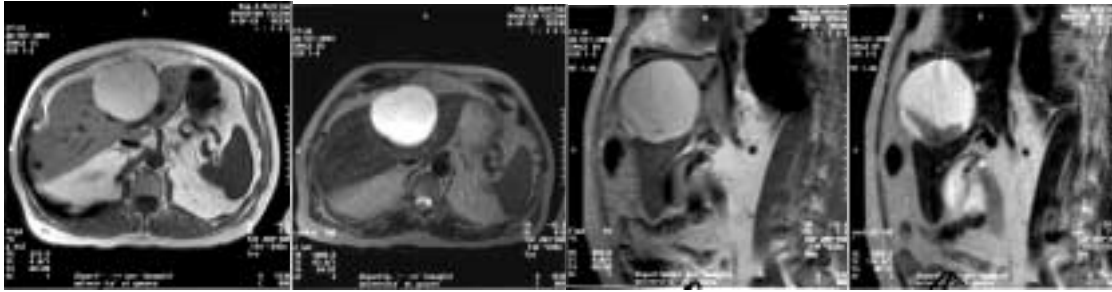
MRI of the cyst: Observable, partly in c) and clearly in d) is the imaging of clots in a slanting position.
